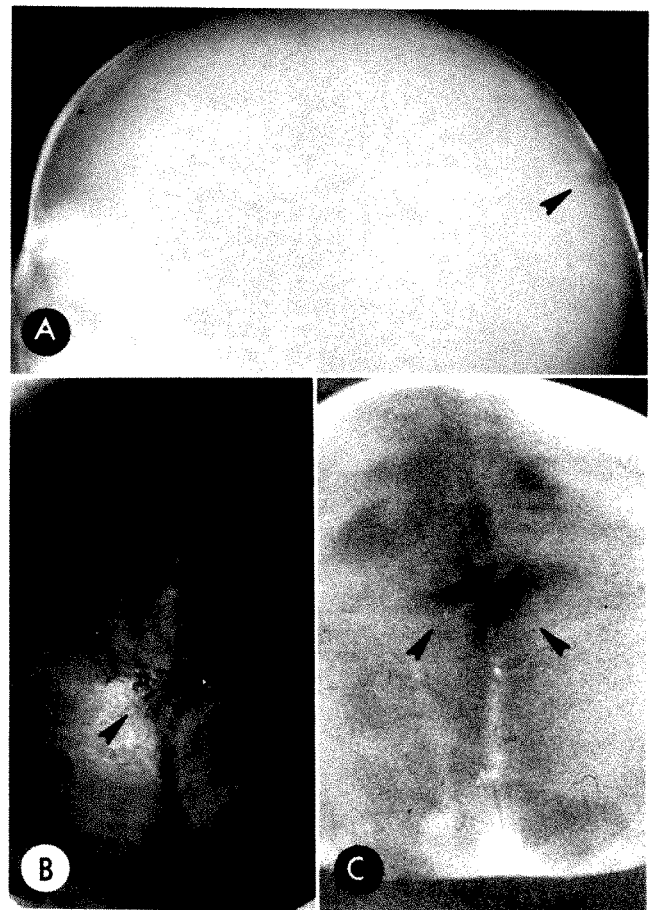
Small parietal fontanelle in newborn infant (arrows). *A*, lateral projection during life. *B*, Postmortem photograph of vertex of head with scalp and pericranium removed. Considerable amount of blood oozed from lateral aspects of posterior fontanelle at time of dissection. *C*, Post-mortem roentgenogram of cranial vault.
